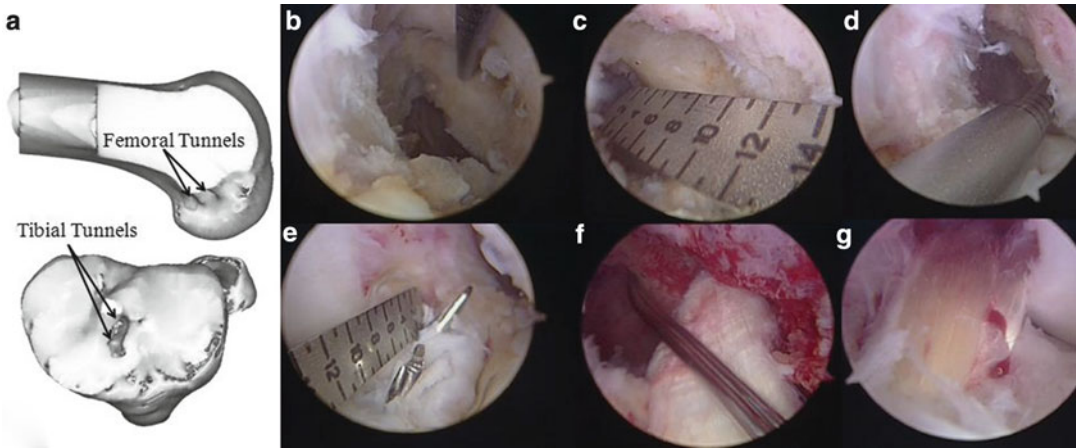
Anatomic double bundle revision surgery after a primary anatomic ACL double bundle reconstruction. (a) 3D-CT scan showing double bundle anatomic placement.
